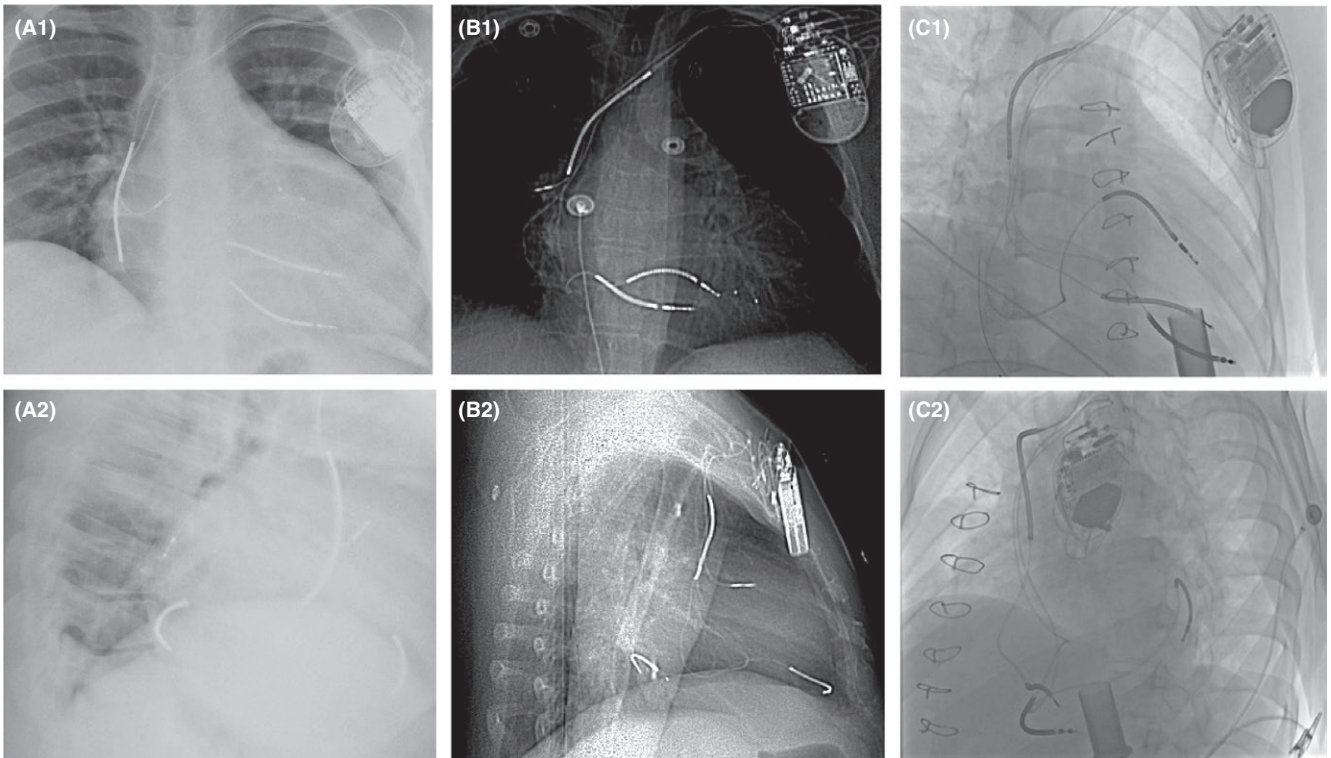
Chest radiograph of cases 4-6, respectively, presented in Table 1, showing the final position of the coronary sinus coil. Postero-anterior fluoroscopic view (A1; B1; C1; D1) and lateral fluoroscopic view (A2; B2; C2; D2)
